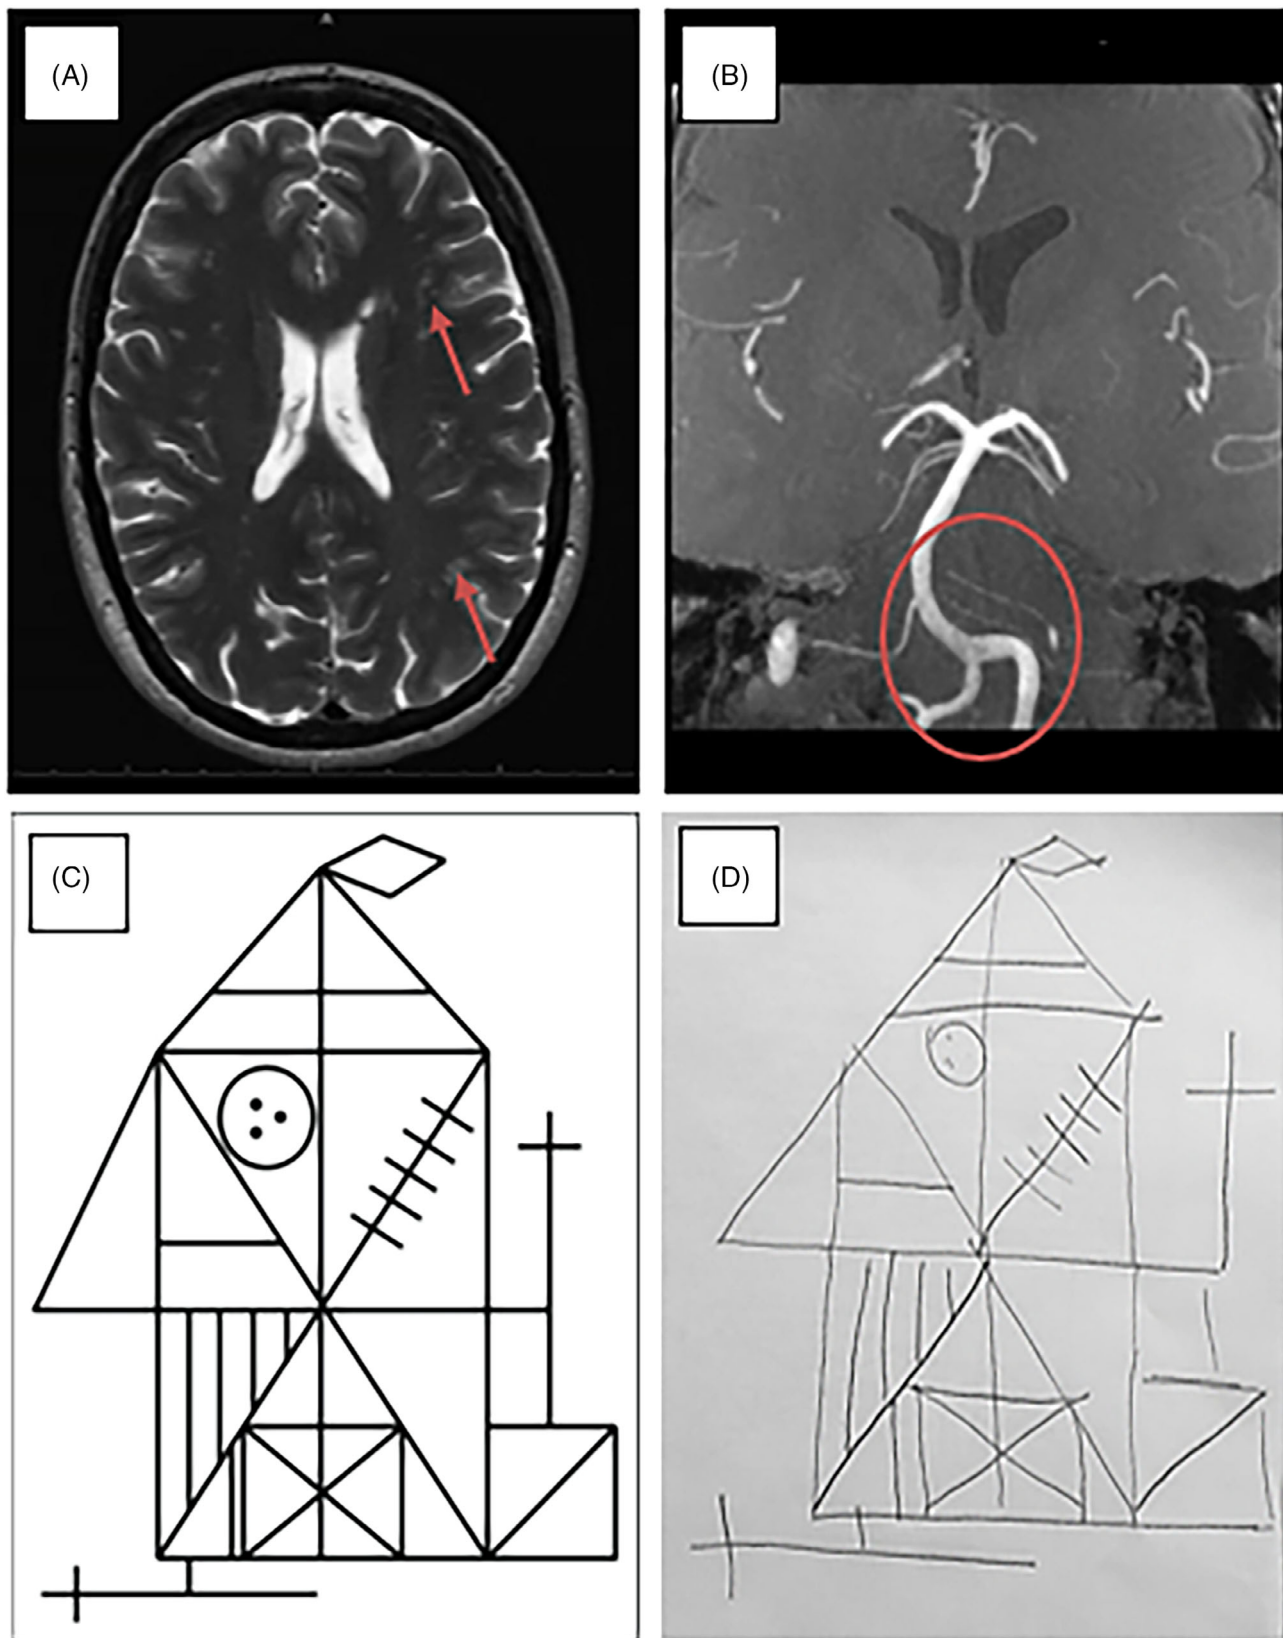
Brain MRI and Rey complex figure test (RCFT) in late-onset Pompe patients. A, T2 image, periventricular, and subcortical WM hyperintensities, Fazekas score 1 to 2 (patient 16). B, MRA-TOF, vertebrobasilar dolichoectasia, diameter 4 mm (patient 18). C, RCFT template. D, Example of RCFT in which patient used a fragmented approach in figure copying. MRA-TOF, Magnetic resonance angiography–time of flight; WM, white-matter
